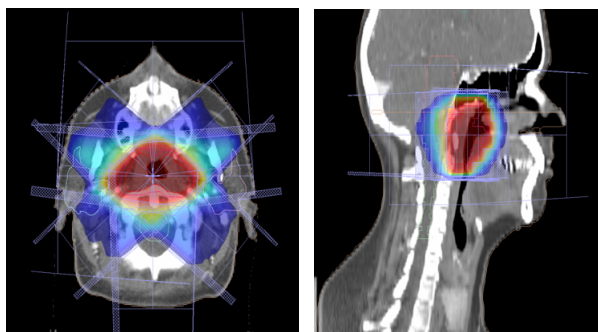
CT axial and sagittal slice showing CTV (red), PTV (pink) and dose distribution (color wash)
